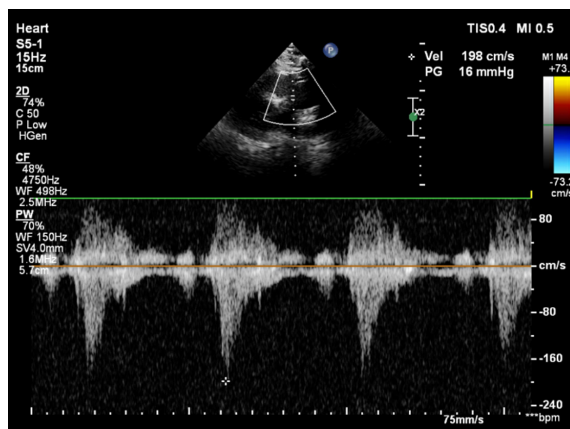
Transthoracic echocardiography confirmed that the narrow part of kinked graft and its pressure gradient was 16 mm Hg and the velocity of blood flow was 198 cm/s.
